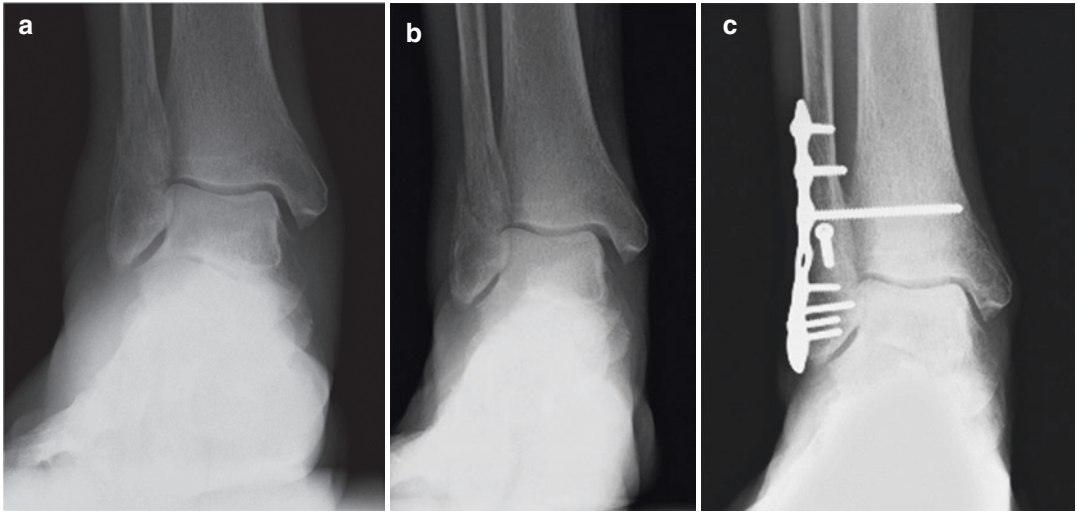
Emergency Room radiographs of a similar patient with ankle pain following an injury (a). Weight-bearing radiograph at 1 week demonstrating unstable ankle fracture (b). Radiograph following successful open reduction internal fixation (c). (Used with permission of Jeremy McCormack)
